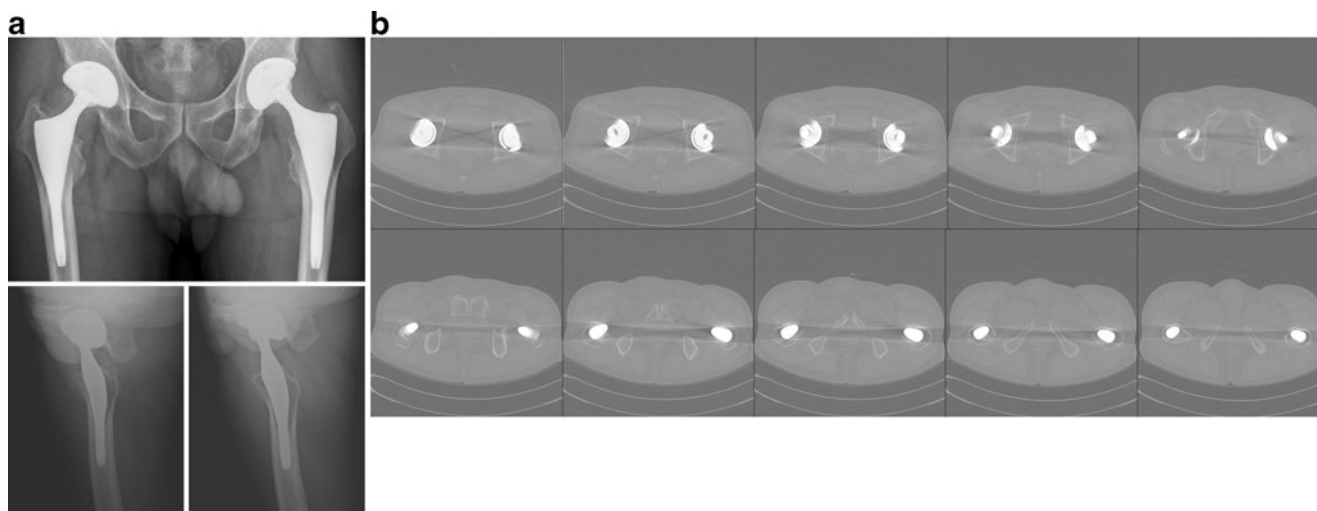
Radiographic and computed tomographic (CT) scanning evaluation of osteolysis of both hips of a 43-year-old man with osteonecrosis of both hips. a An anteroposterior radiograph of both hips 10 years after surgery demonstrated that Duraloc optional cementless cups are fixed in a satisfactory position by bone ingrowth.
